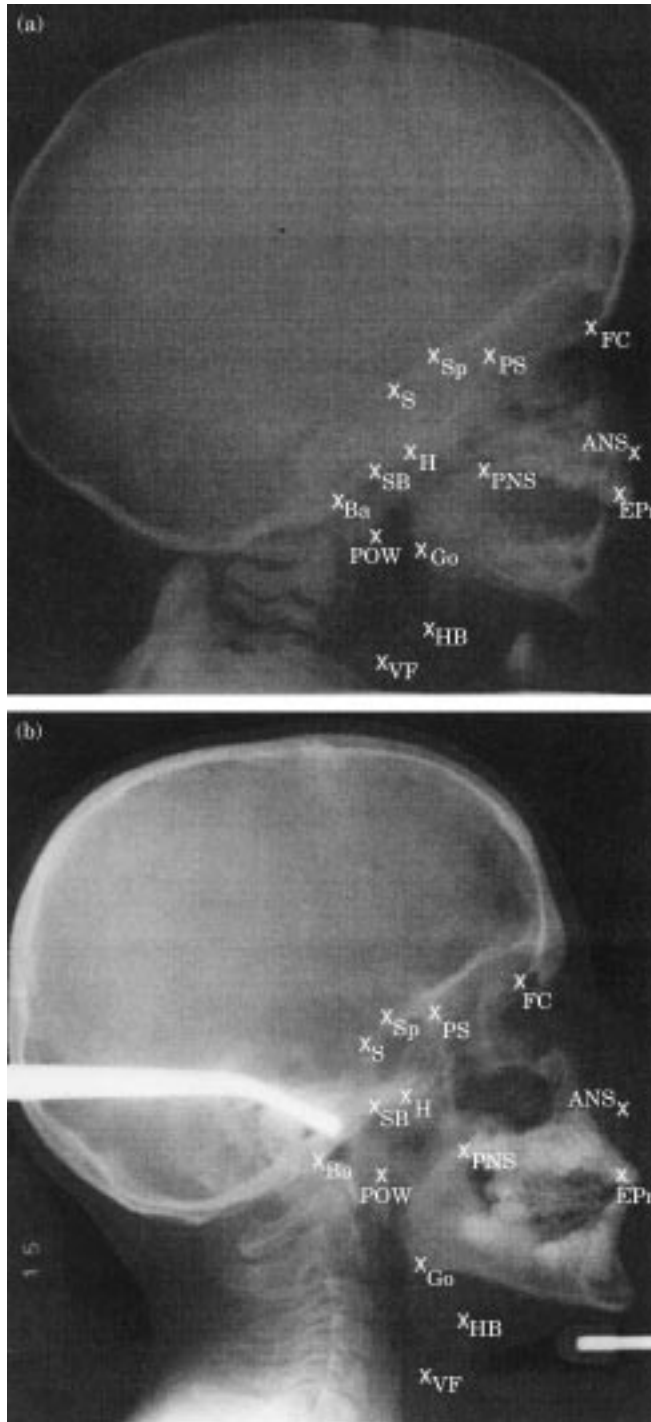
Lateral view radiographs of two individuals from the Denver Growth Study, showing location and visibility of landmarks used in this study. (a) infant, No. 557, aged 9 months; (b) juvenile, No. 515, aged 9 years 9 months. Landmarks are defined in Table 2, and discussed in text.
